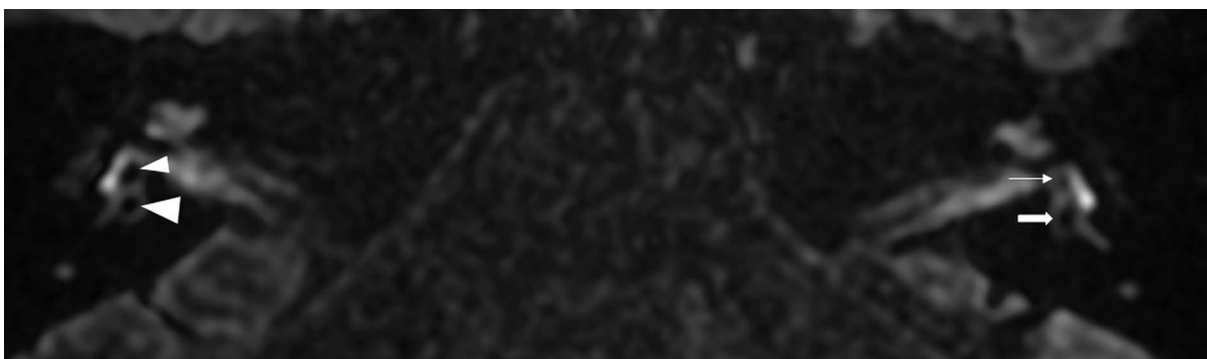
Magnetic resonance image of a 36-year-old male (patient #4) with right-sided clinically defined Ménière's disease. According to the Bernaerts classification [13], it is an example case of grade 1 (extra-low) vestibular hydrops. On the Barath scale [11], it is grade 0, presenting no signs of VH. Delayed-postcontrast 3D-FLAIR T2 axial image of both ears below the mid-modiolar level (inferior part of the vestibule). The right saccule (small arrowhead) is slightly bigger than the utricle (marked with an arrowhead), but the vestibular structures are still separated. Compared with a left unaffected side, the saccule (marked with a thin arrow) is smaller than the utricle (marked with a thick arrow)
